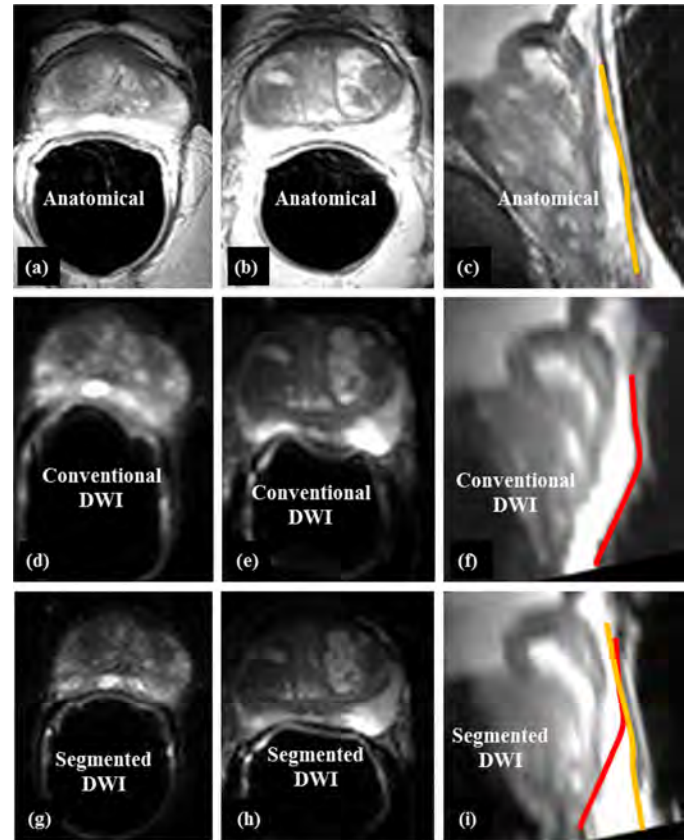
Comparison of anatomical T2W (top row, a-c), conventional DWI (middle row, d-f), and accelerated segmented DWI (g-i). Accelerated segmented DWI provides high-resolution images with good geometric fidelity and SNR. The left and middle columns show images in the axial plane, the rightmost column in the sagittal plane. The 'reference' rectal wall shape is seen in (c), orange line, and the distorted shape in (f), red line. In the segmented-accelerated results in (i), the rectal shape (bright signal) is in much closer agreement with the correct shape of (c), orange line, than that of (f), red line. In other words, geometric fidelity is considerably restored using accelerated segmented DWI (i).
